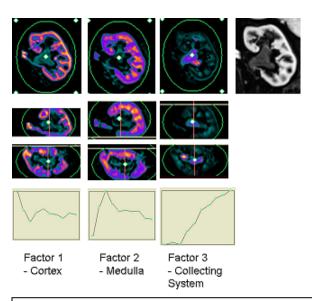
Factor Images (color images) and Time-Intensity Curves (bottom row) in a Normal Kidney. Contrast-enhanced T1-weighted MR image (top right).
